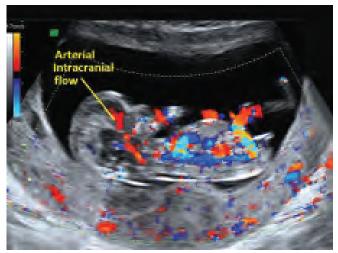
Early fetal circulation color Doppler
